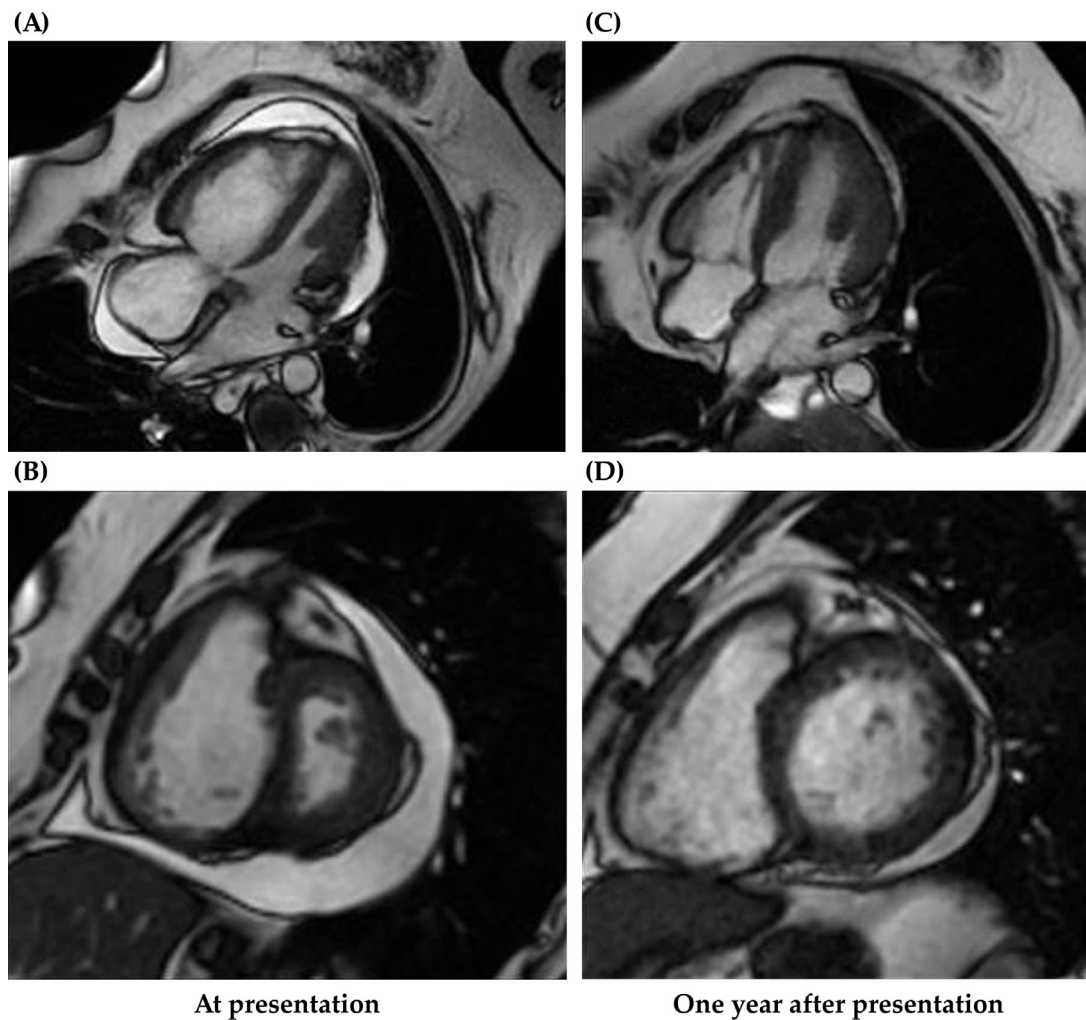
An example of cardiac MRI in a SSc patients for ongoing serial monitoring of treatment response. Upper side: end-systolic images showing right ventricular enlargement and pericardial effusion before (A) and after starting combination therapy for PAH with bosentan, sildenafil, and iloprost inhalation (C). Lower side: short axis of the right and left ventricle before (B) and after starting combination therapy (D). Adapted from Garau et al. [127].
